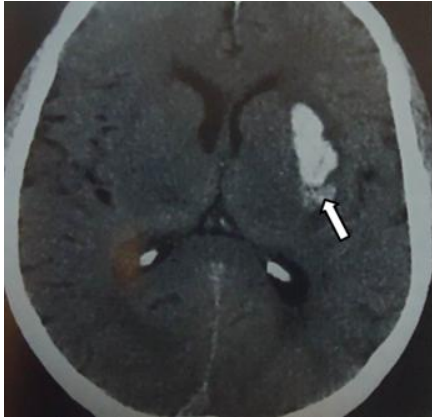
CT image of putaminal hematoma
